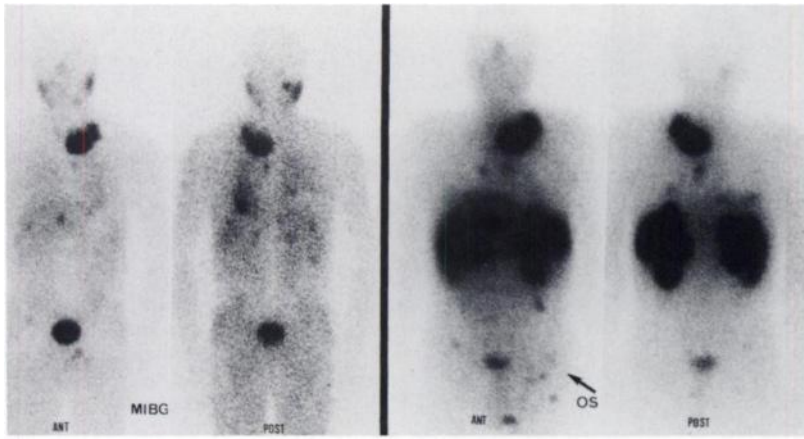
Patient 14 with a malignant ganglioneuroblastoma. Presentation as in Figure 1. Multiple foci corresponding to already known tumor sites (CT scan): a left cervical lymph node, bilateral lung metastases, a right pterygo-maxillar metastasis, costal metastases and liver metastases. Three pelvic foci are visible only on octreotide scintigraphy (arrow) and could not be explained.
